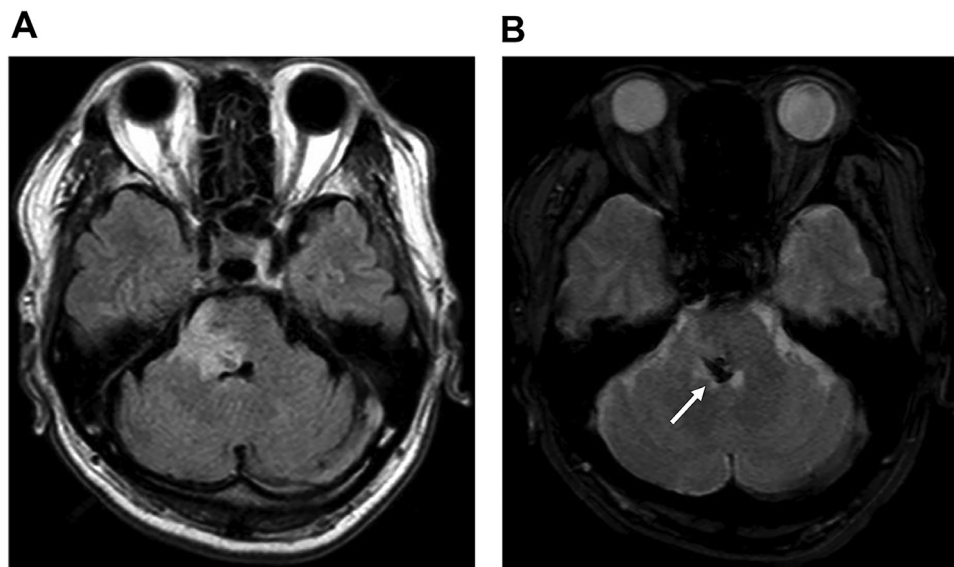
MRI imaging after 2nd TVE A: Fluid-attenuated inversion recovery image- Brain MRI after the second TVE showing deteriorated pons edema (A). B: T2* image- Arrow: pons hemorrhage MRI, magnetic resonance image; TVE, transvenous embolization.
